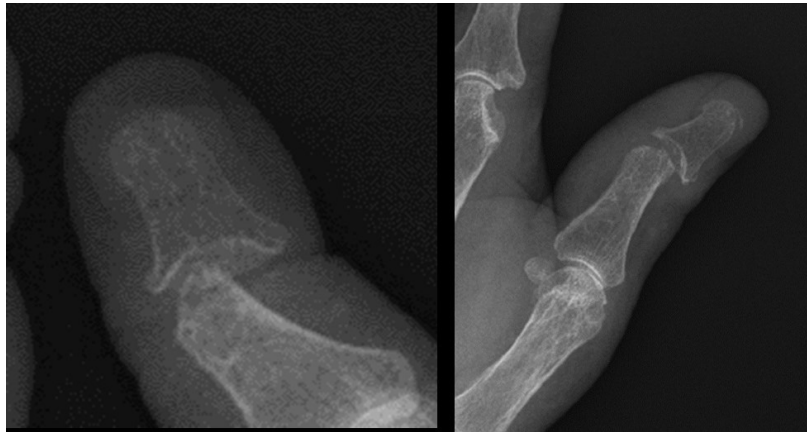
Conventional radiographs of the left thumb of a patient with psoriatic arthritis show the pencil-in-cup deformity of the IP joint.
